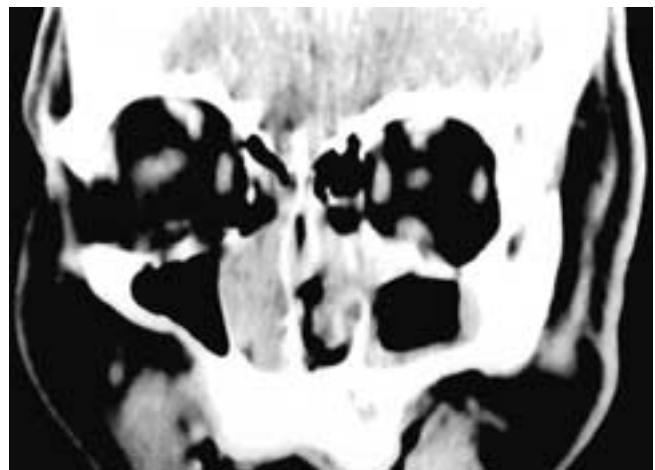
Coronal CT scan shows an expansile polypoid mass in the right nasal fossa (arrowhead). There is no bone erosion, and the nasal septum is intact. Inflammatory disease is present in the left antrum and nasal cavity. This patient had a fibrous histiocytoma.
